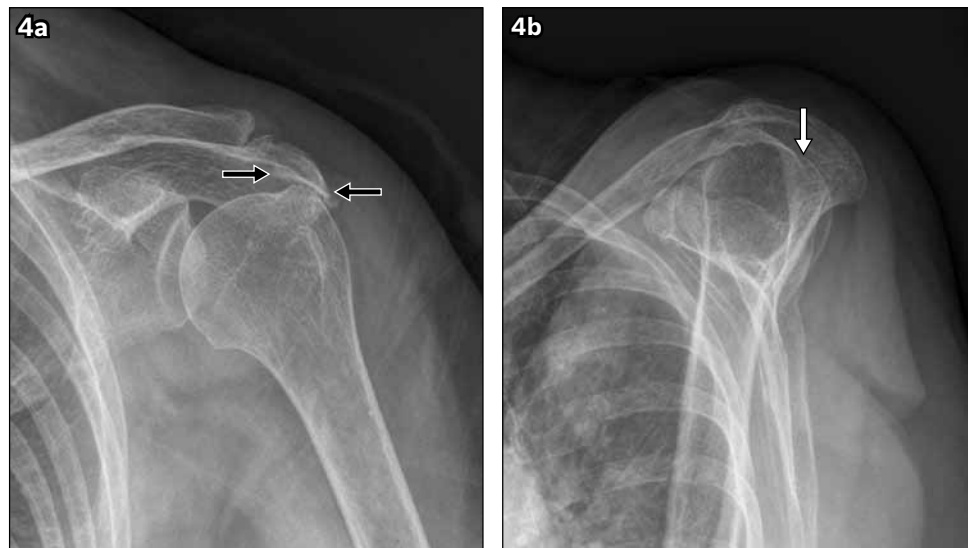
(a) Frontal and (b) transcapular shoulder radiographs of a patient with full-thickness chronic rotator cuff tear show acromial and humeral osteophyte formation (black arrows) with superior migration of the humeral head (white arrow).
